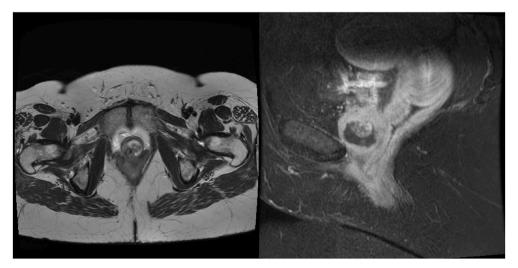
MRI pelvis of Patient A. Urethral diverticulum with an enhancing filling defect representing urethral adenocarcinoma.
